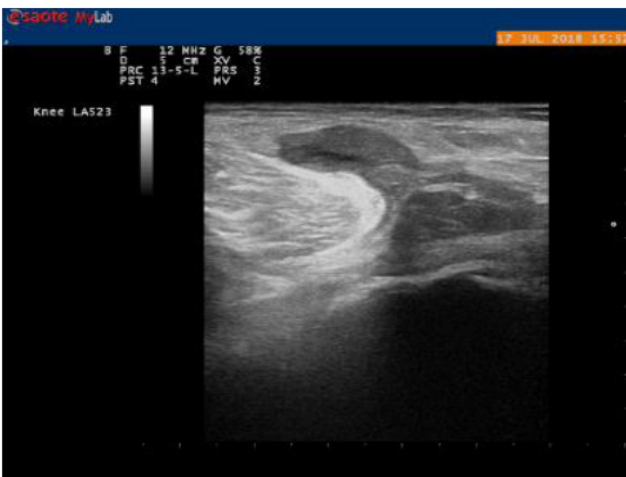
Ultrasound of the knee.
